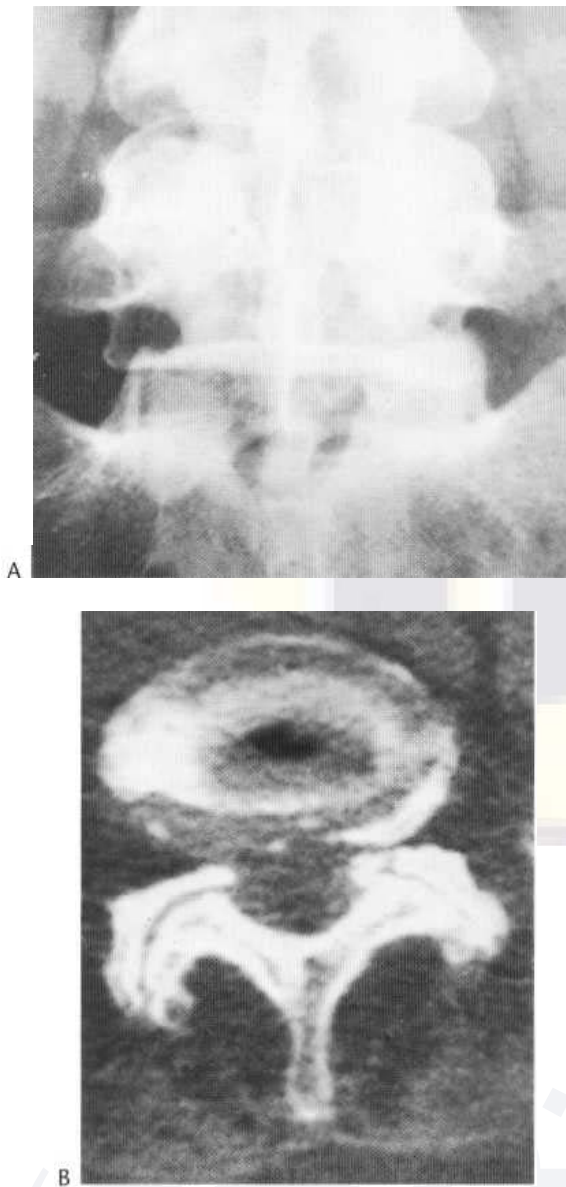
(A) The facet joints are no longer symmetrical and show features of degeneration. (B) The CT scan shows gross new bone formation around narrowed facet joints. There is marked bony encroachment upon the exit foramina, especially the left. Gas is seen in the disc (vacuum phenomenon).
